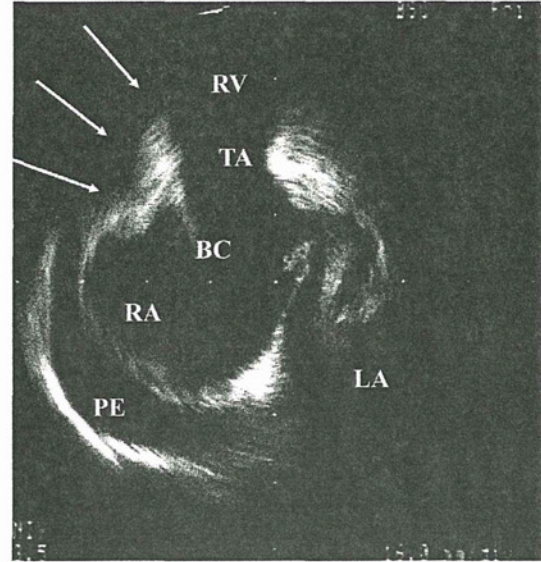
Intracardiac echocardiographic image shows the biopsy catheter (BC) next to the cardiac tumor (white arrows) protruding into the right atrium (RA) and right ventricle (RV). PE, pericardial effusion; TA, tricuspid valve annulus; LA, left atrium.
